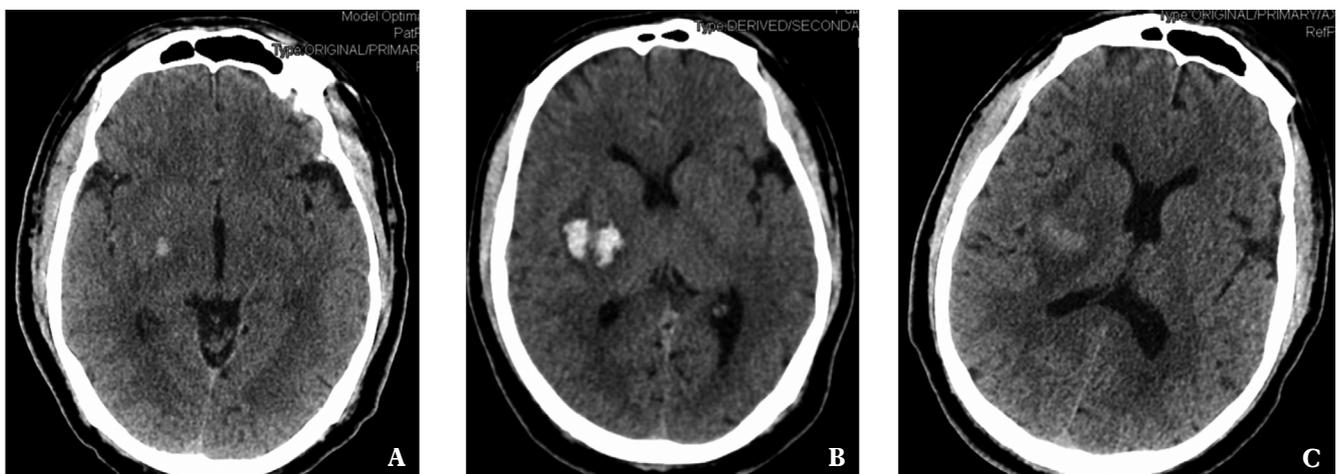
Several CT scans of the brain showing the progression of the haemorrhagic lesion at different times: at baseline (A), at 24 hours (B) and after 1 week (C).
